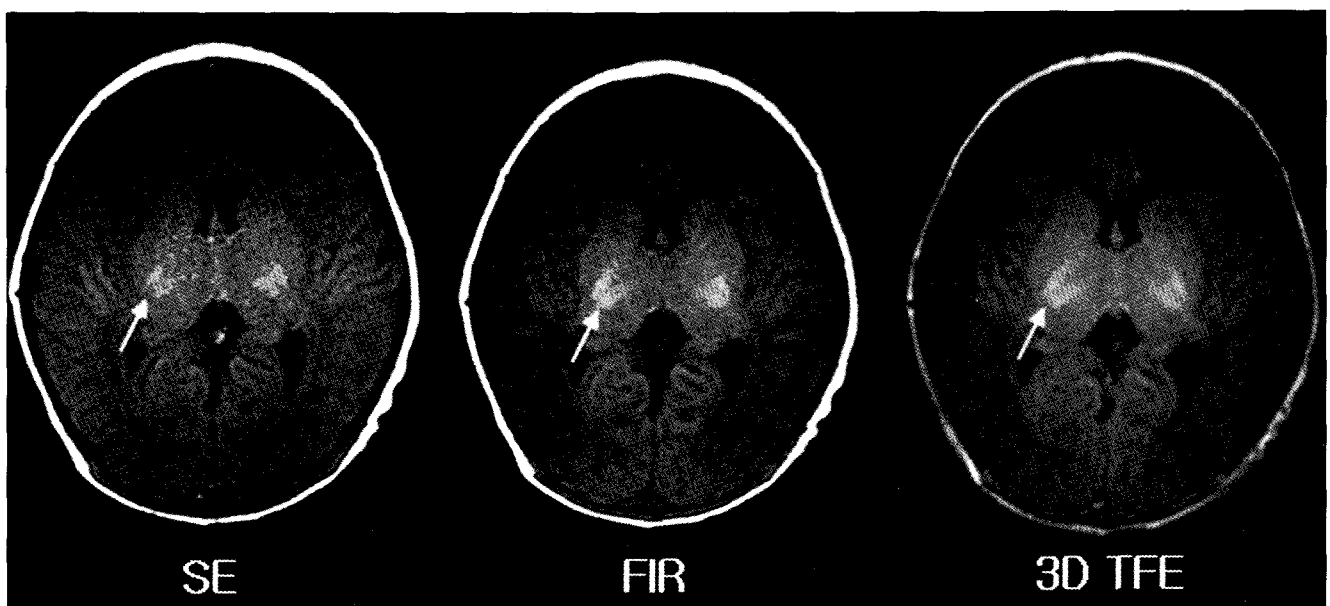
Comparison of three different T1 weighted images. Gray-white matter differentiation and conspicuity of myelination (arrow) in the thalamus were superior in the FIR, 3D GRE compared to the SE T1-weighted images. (SE : spin echo sequence, FIR : fast inversion recovery sequence, 3D TFE; magnetization-prepared three-dimensional gradient echo sequence)
